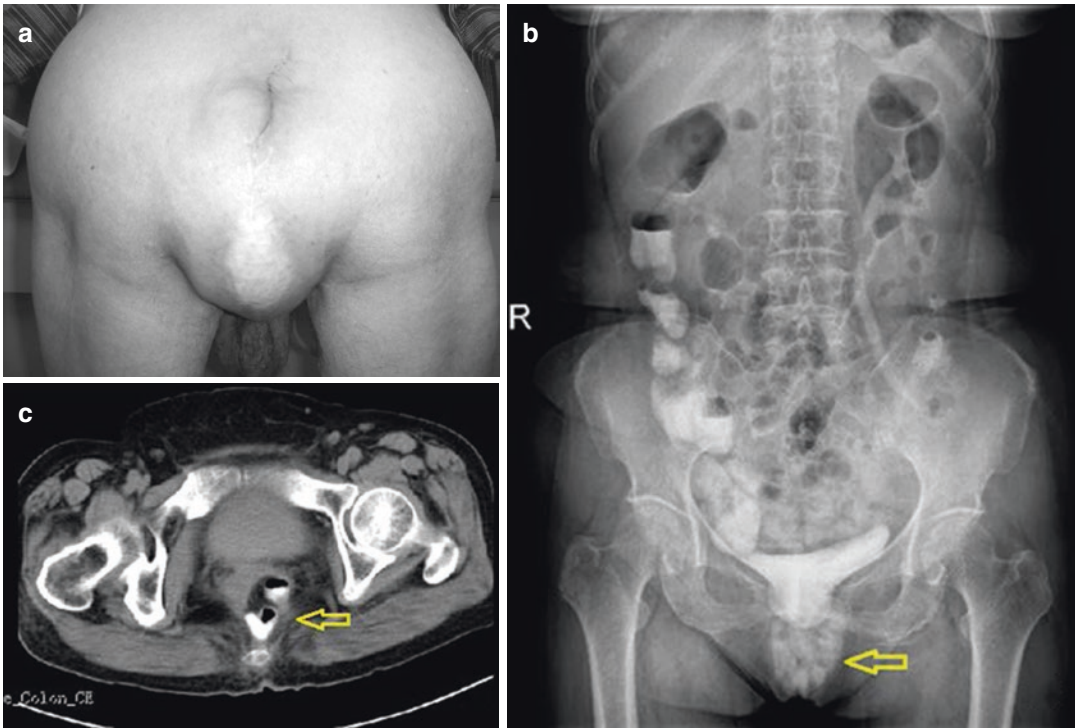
(a) Preoperative picture showing the perineal hernia defect; (b) X-ray of the abdominal orthostatic showing hernia; (c) Computed tomography (CT) scan showing
